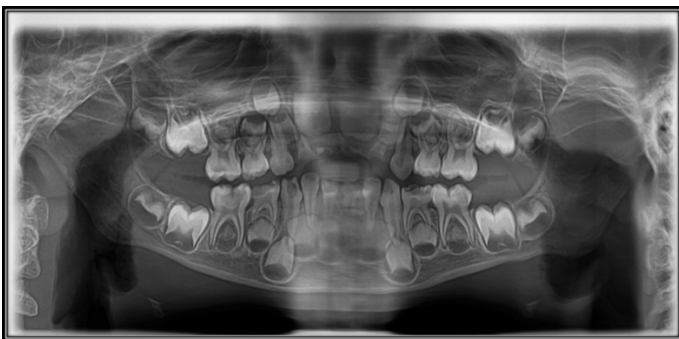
Orthopantomograph showing Type III ECC
